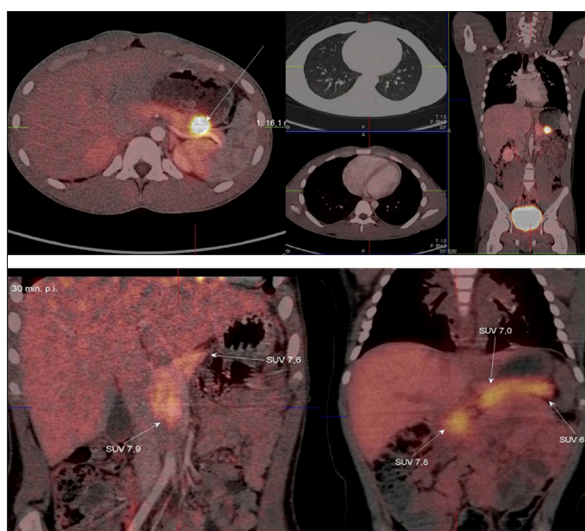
^{18}F -fluoro-L-DOPA PET/CT in focal CHI (top image) and diffuse CHI (bottom image).
